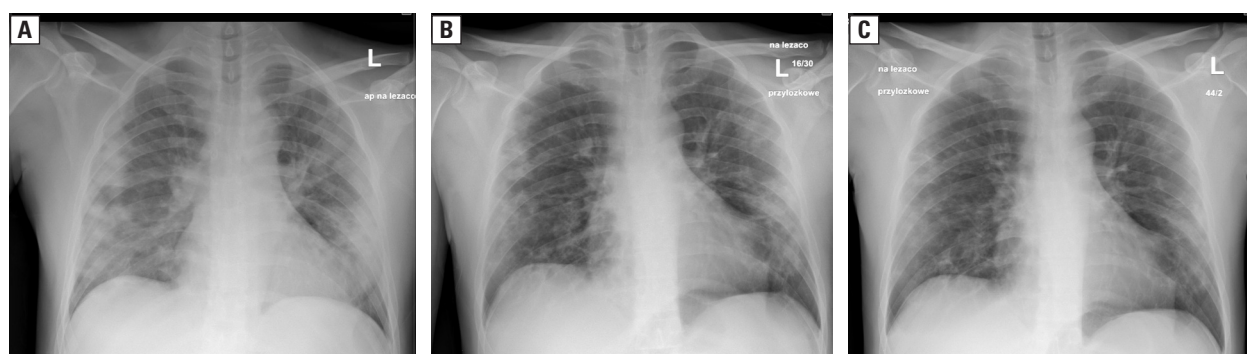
The course of COVID-19 in 37-year-old male in chest radiograph examinations. A. The admission day: disseminated parenchymal opacities in both lungs. B. 5th day of hospitalization. C. 16th day of hospitalization. Visible gradual regression of the lesions. The patient with respiratory failure — required the use of oxygen with nasal cannula (flow 5 L/min). On day 16th the patient without hypoxemia
